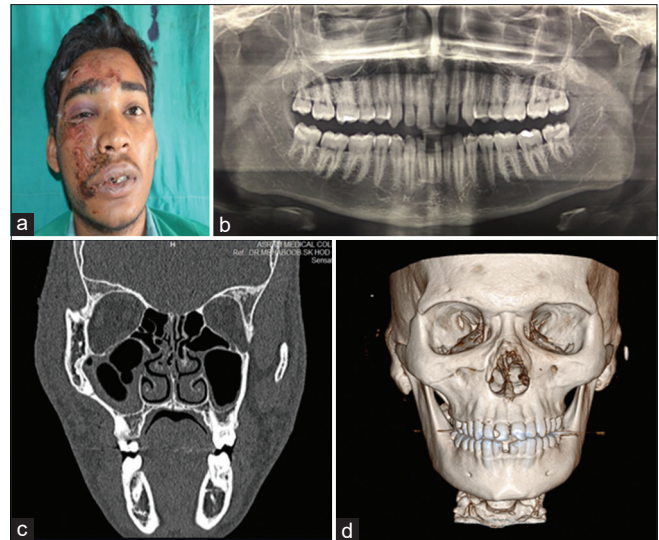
(a) Pre-op profile, (b) Pre-operative radiograph, (c) multidetector computed tomography (MDCT), (d) 3D- MDCT
